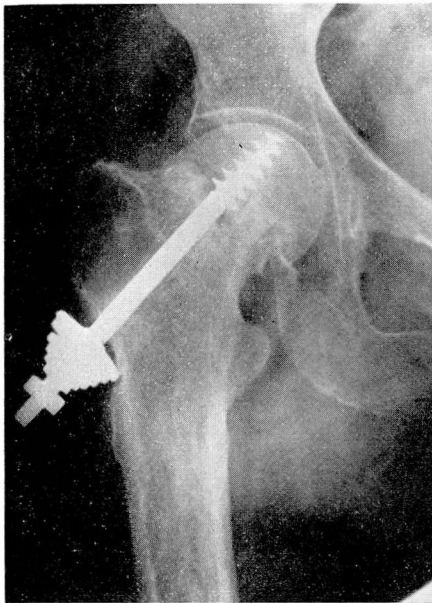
Preoperative roentgenogram showing nonunion.
